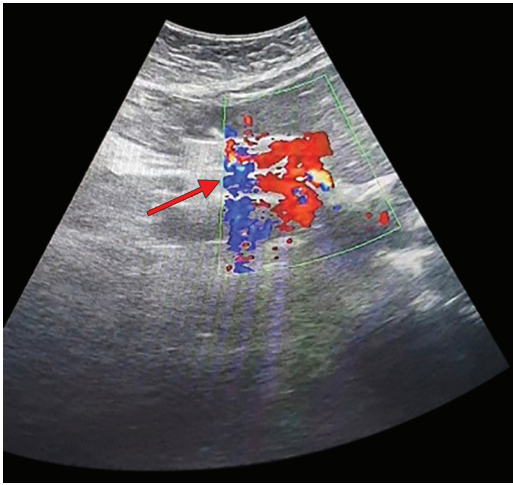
Under ultrasonography long axis showing dispersion of fluid and disappearance of classical “Trident sign” (shown by arrow)
